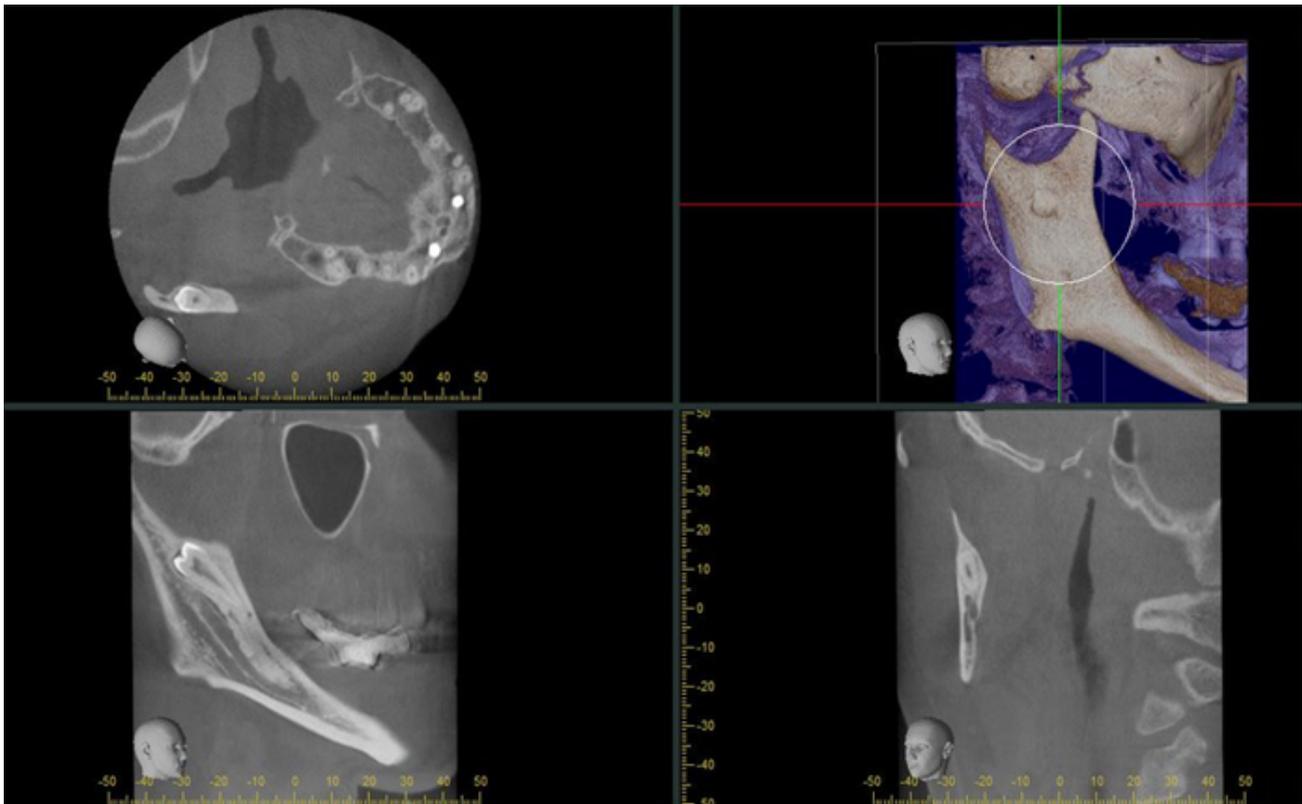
A heterotopic right mandibular third molar tooth in the mandibular ramus on coronal, axial and sagittal CBCT sections. White arrows show the heterotopic teeth.
